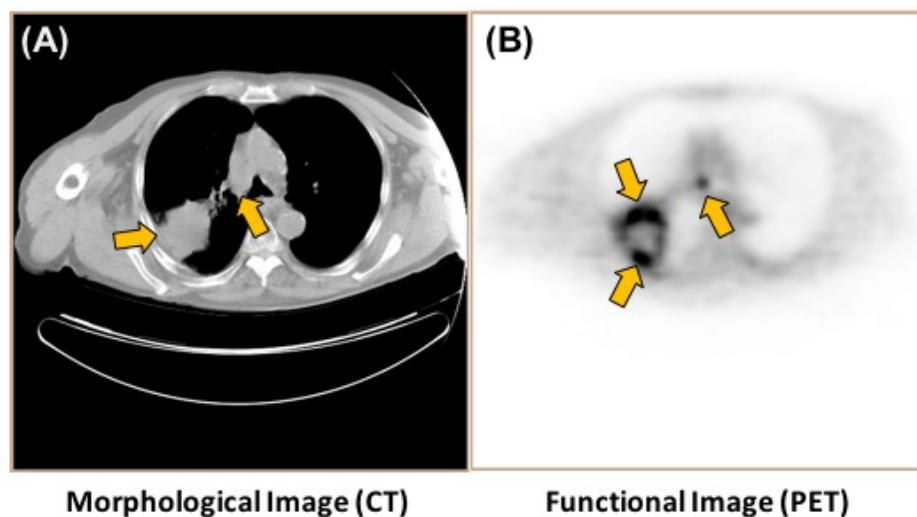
Hybrid PET/CT imaging offers complimentary information in one scan
